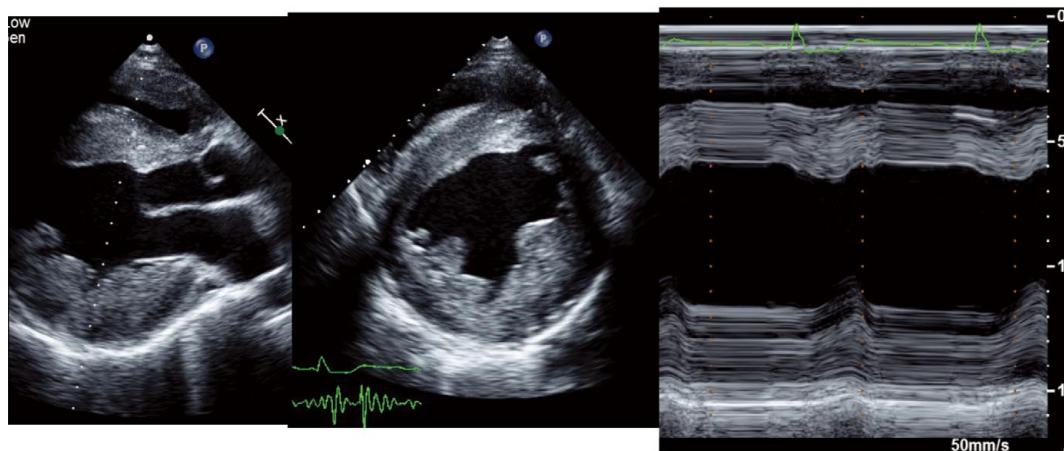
Echocardiographic assessment of the proband. Parasternal long-axis view, M mode and short-axis view show marked concentric hypertrophy with dilatation of the left ventricle (70 mm at end-diastole). The interventricular septum is 22 mm thick and the left ventricular posterior wall is 23 mm. Wall motion of the left ventricle is depressed, as shown by a decrease in the ejection fraction (0.42). These findings are suggestive of the dilated phase of hypertrophic cardiomyopathy.
